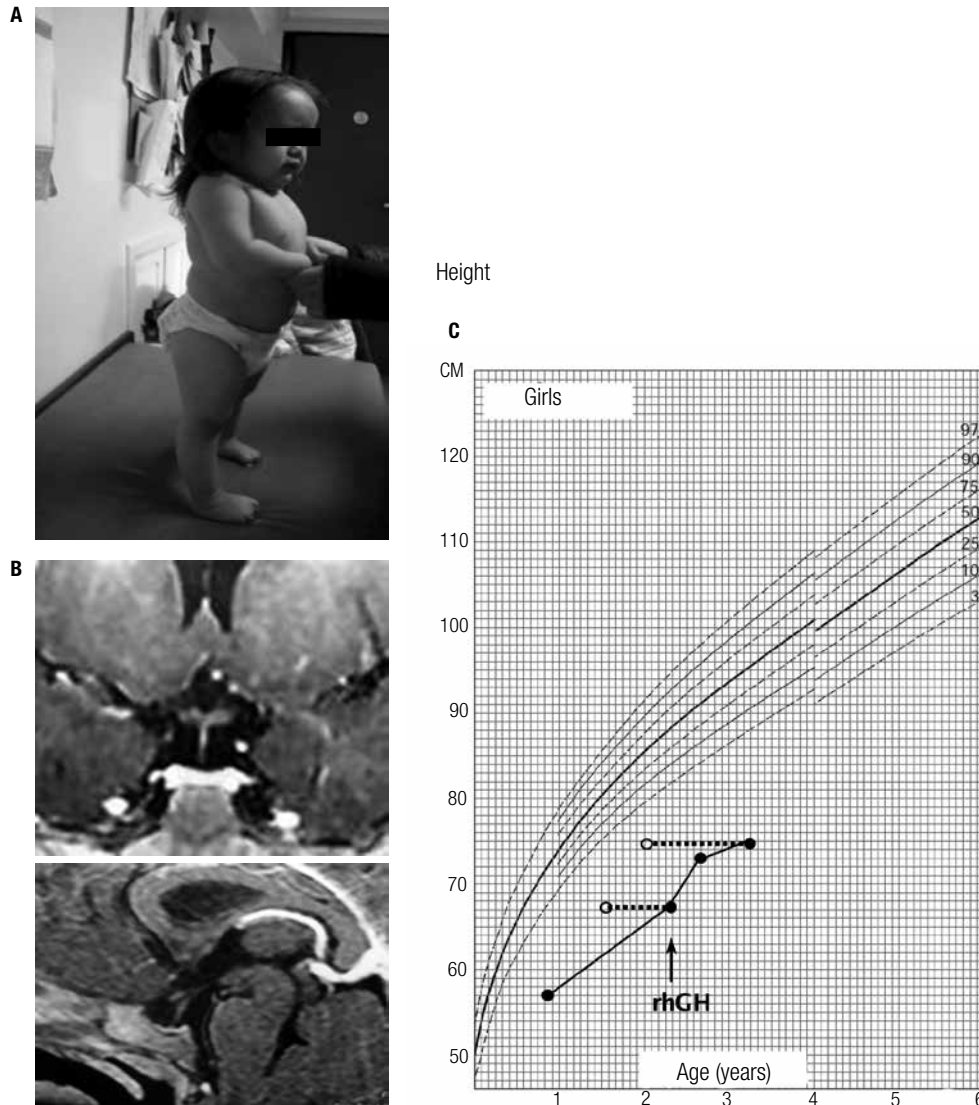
A. Patient at 1.8 years of chronological age (written consent for publication was obtained from the parents). B. Brain MRI showing pituitary hypoplasia. C. Growth chart. Closed circles: height for chronological age. Open circles: bone age.
